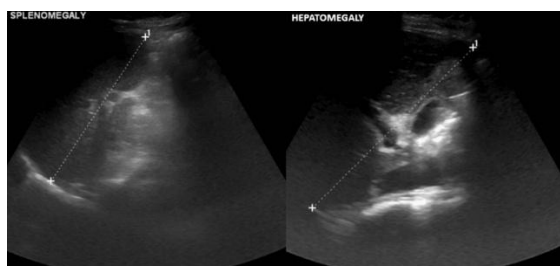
Ultrasound abdomen of case 1 showing borderline splenomegaly and mild hepatomegaly
